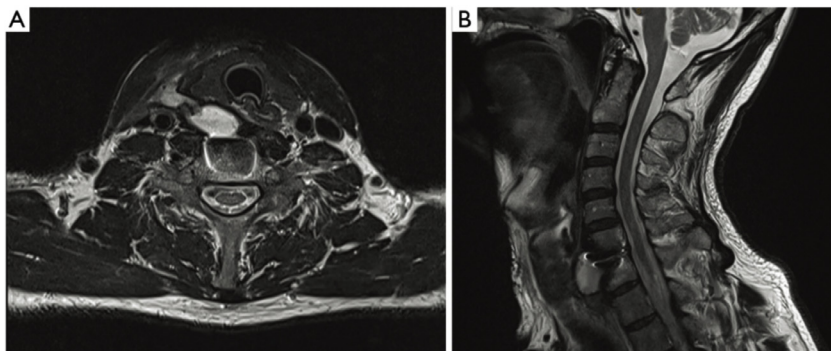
Pre-operative MRI showing prevertebral fluid collection. (A) Axial T2, (B) sagittal T2. Reproduced from Xia and Winder [39].
